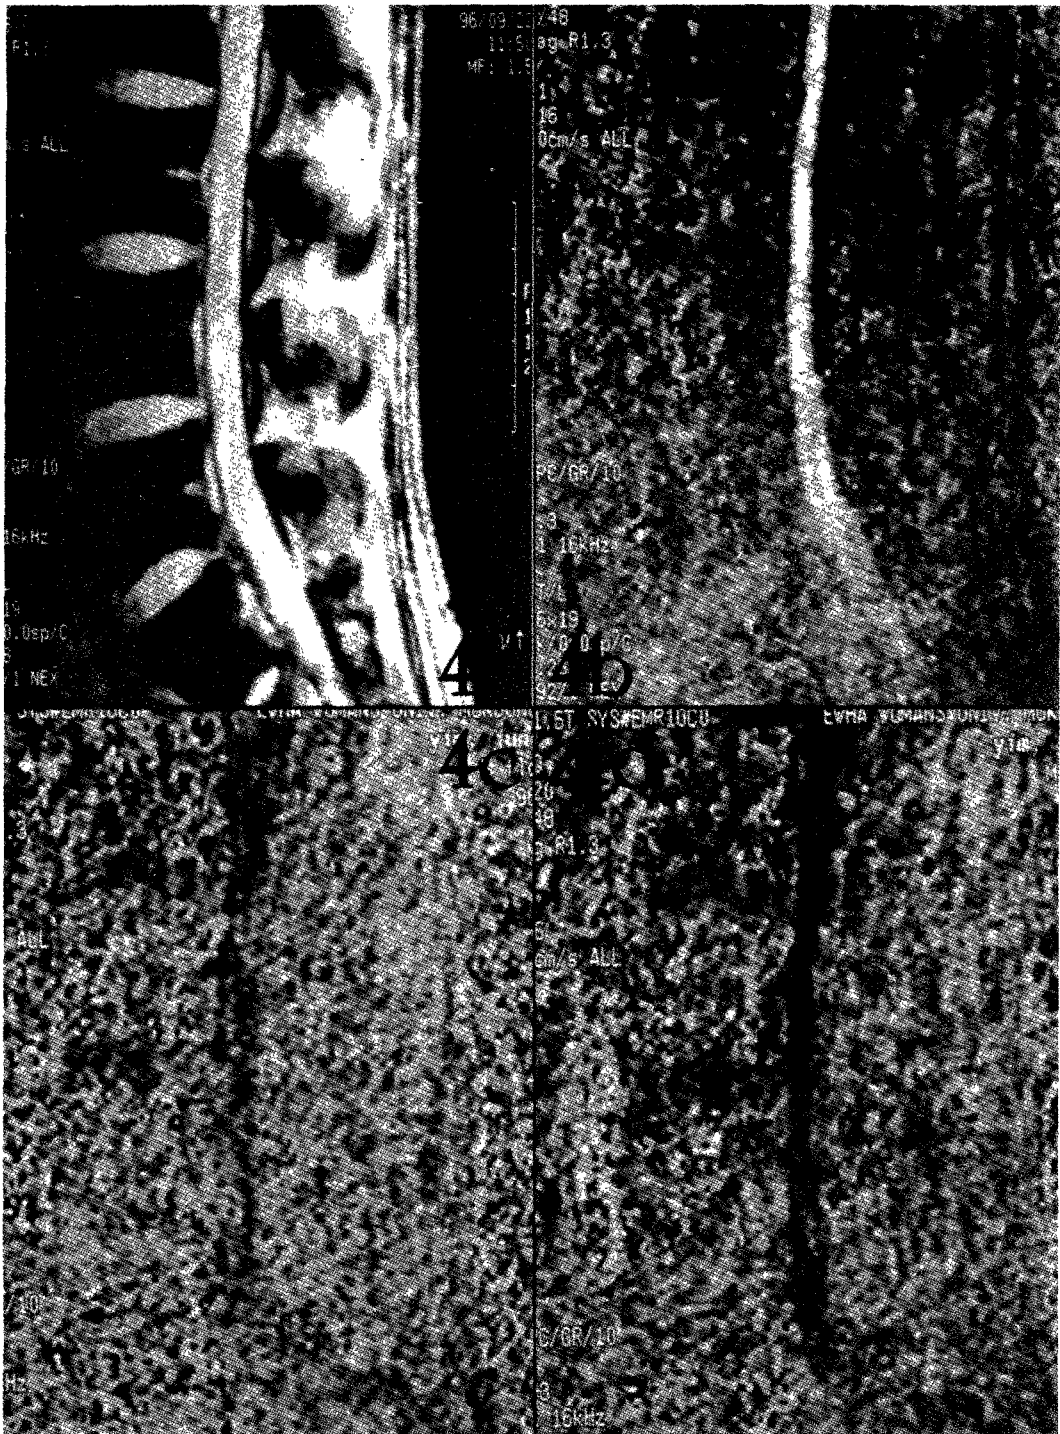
Sagittal plain and velocity-encoded images of lumbar level in normal person. A sagittal Plain MR image showing the anatomical detail around the cauda equina in 4a. Systolic peak flow(white) is seen in 4b, and diastolic peak flow(black) is seen in 4d. Inversion of systolic to diastolic flow is seen in 4c(Note relatively indefinite signal changes through the cul de sac).
